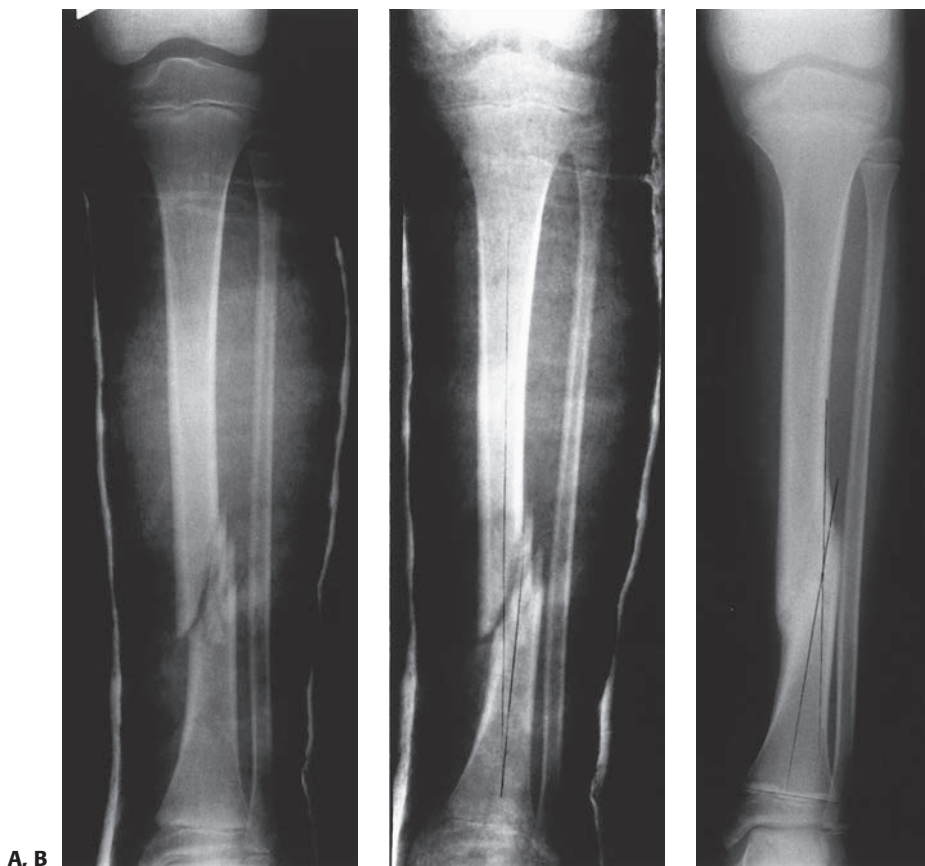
Anteroposterior radiograph of a distal one-third tibial fracture without concomitant fibular fracture in a 10-year-old child. A: The alignment in the coronal plane is acceptable (note that the proximal and distal tibial growth physes are parallel). B: A varus angulation developed within the first 2 weeks after injury. C: A 10-degree varus angulation was present after union.
